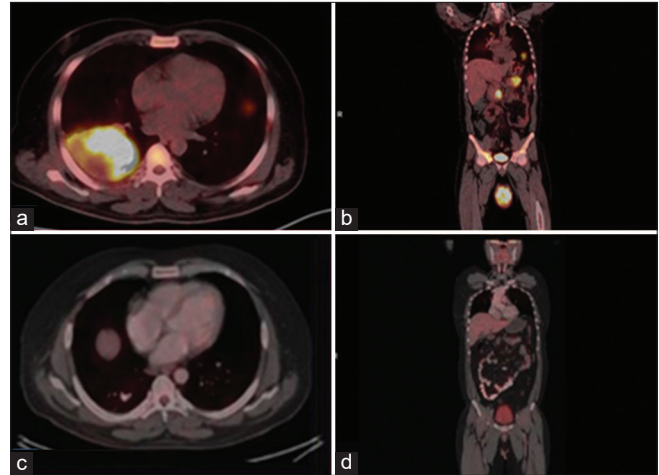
PET-CT at diagnosis (a and b) showing metabolically enhancing right testicular mass lesion, right adrenal, pancreatic, bone lesions with enlarged para-aortic lymph nodes and following three cycles of chemotherapy (c and d) showing metabolic resolution all the lesions.
